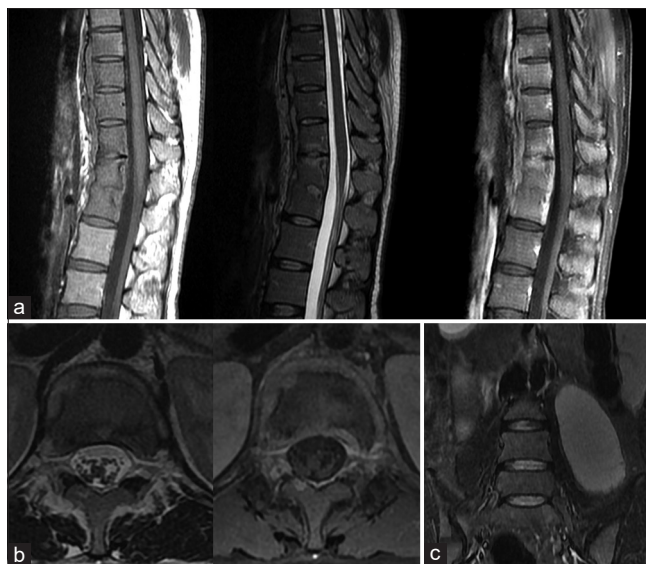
MRI of the spine showing tuberculous involvement. (a) Sagittal, (b) axial, (c) coronal sections showing vertebral body destruction with endplate involvement and slight gibbus formation
